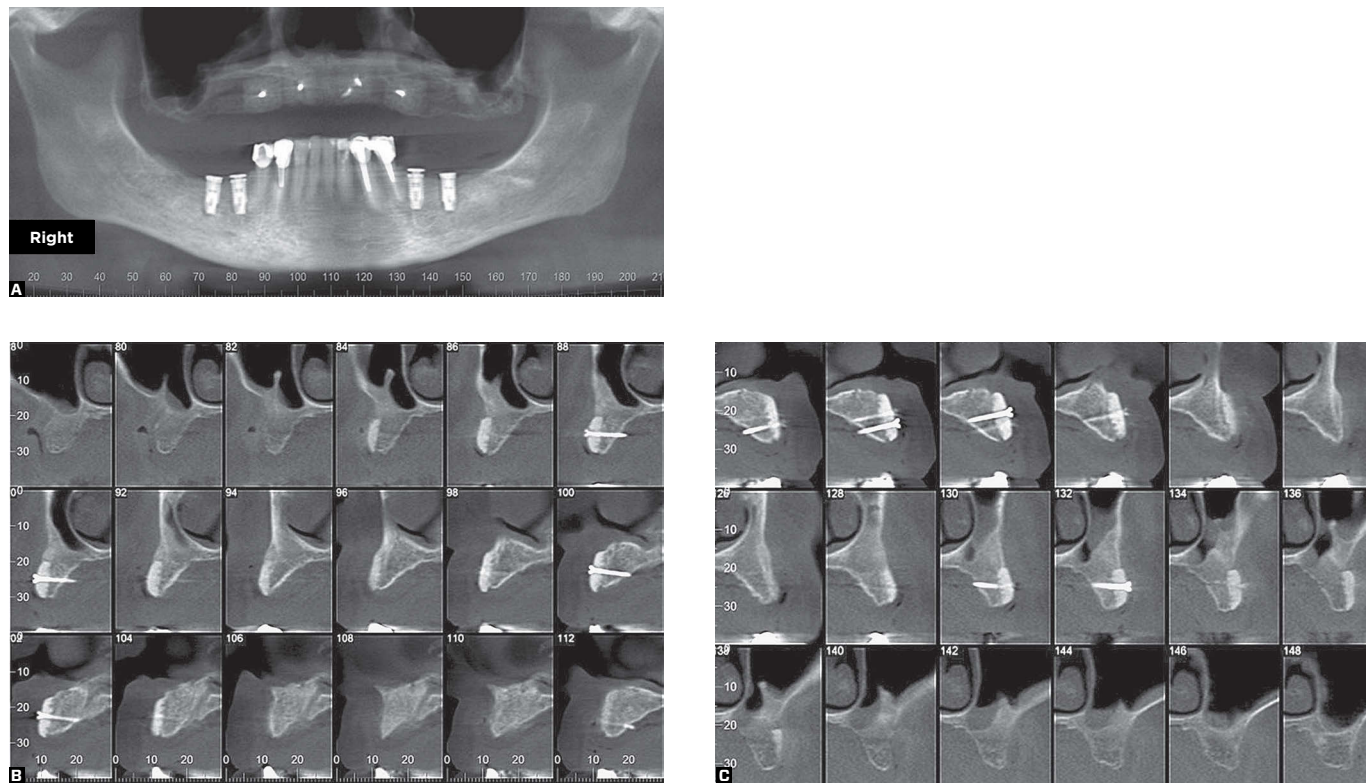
Cone-beam CT - panoramic (A) and transverse (B, C) slices six months after the surgical reconstruction of the maxilla with allograft bone blocks.
